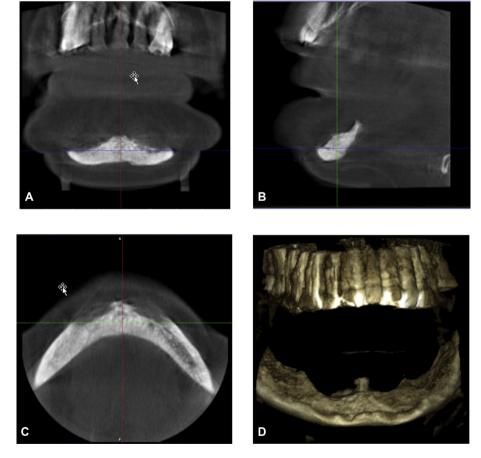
Coronal (A), sagittal (B), axial (C) and reconstructed 3D cone beam computed tomography (D) images revealed intact bone surface of the remaining mandibular cortex after 4 months post surgery, respectively.
